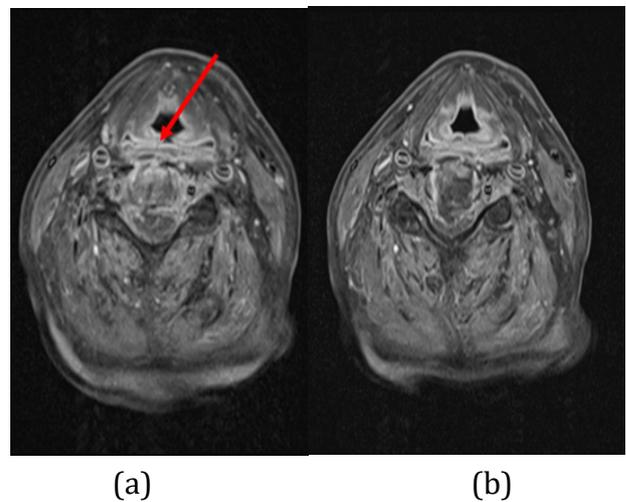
Post-contrast T1-weighted fat-suppressed axial images demonstrate the fissure of the posterior pharyngeal wall on the right side (a, arrowed), the enhancement of the retropharyngeal soft tissue, abscess collection and severe narrowing of the spinal canal (a,b).
